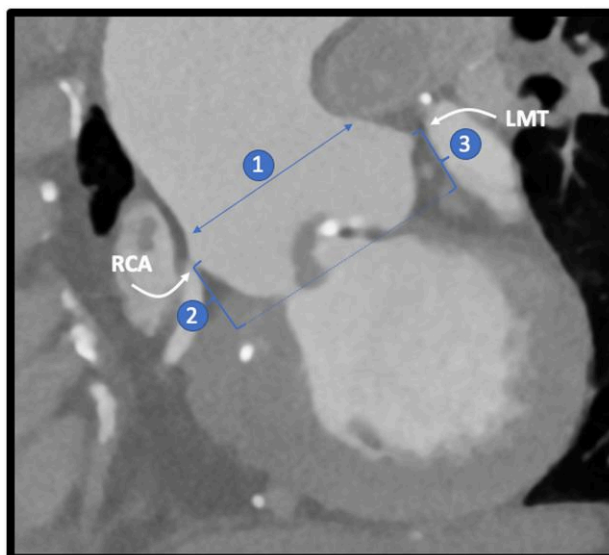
Cardiac computed tomography with geometry analysis of the aortic valve and root in long axis showing few calcifications on the leaflets with a 40 mm a sino-tubular junction¹ and a 16 mm distance between annulus and coronary ostia.^{2,3}
